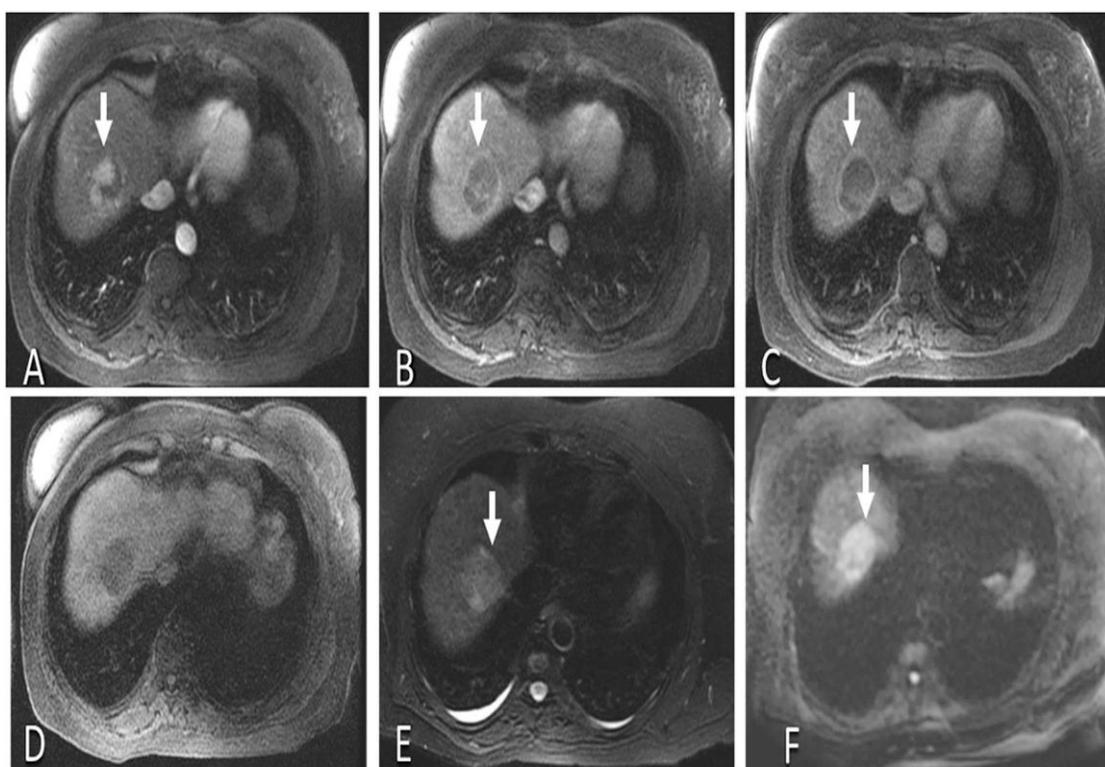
Axial magnetic resonance imaging of the HCC in a 57-year-old patient with cirrhosis secondary to chronic hepatitis C infection. Arterial (A), portal venous (B), delayed (C) phase demonstrating arterial phase hyperenhancement in HCC (arrow) which washes out on portal venous and delayed phases. This mass demonstrates T1 hypointensity (D), and mild T2 hyperintensity (E) with mild restricted diffusion (F).
